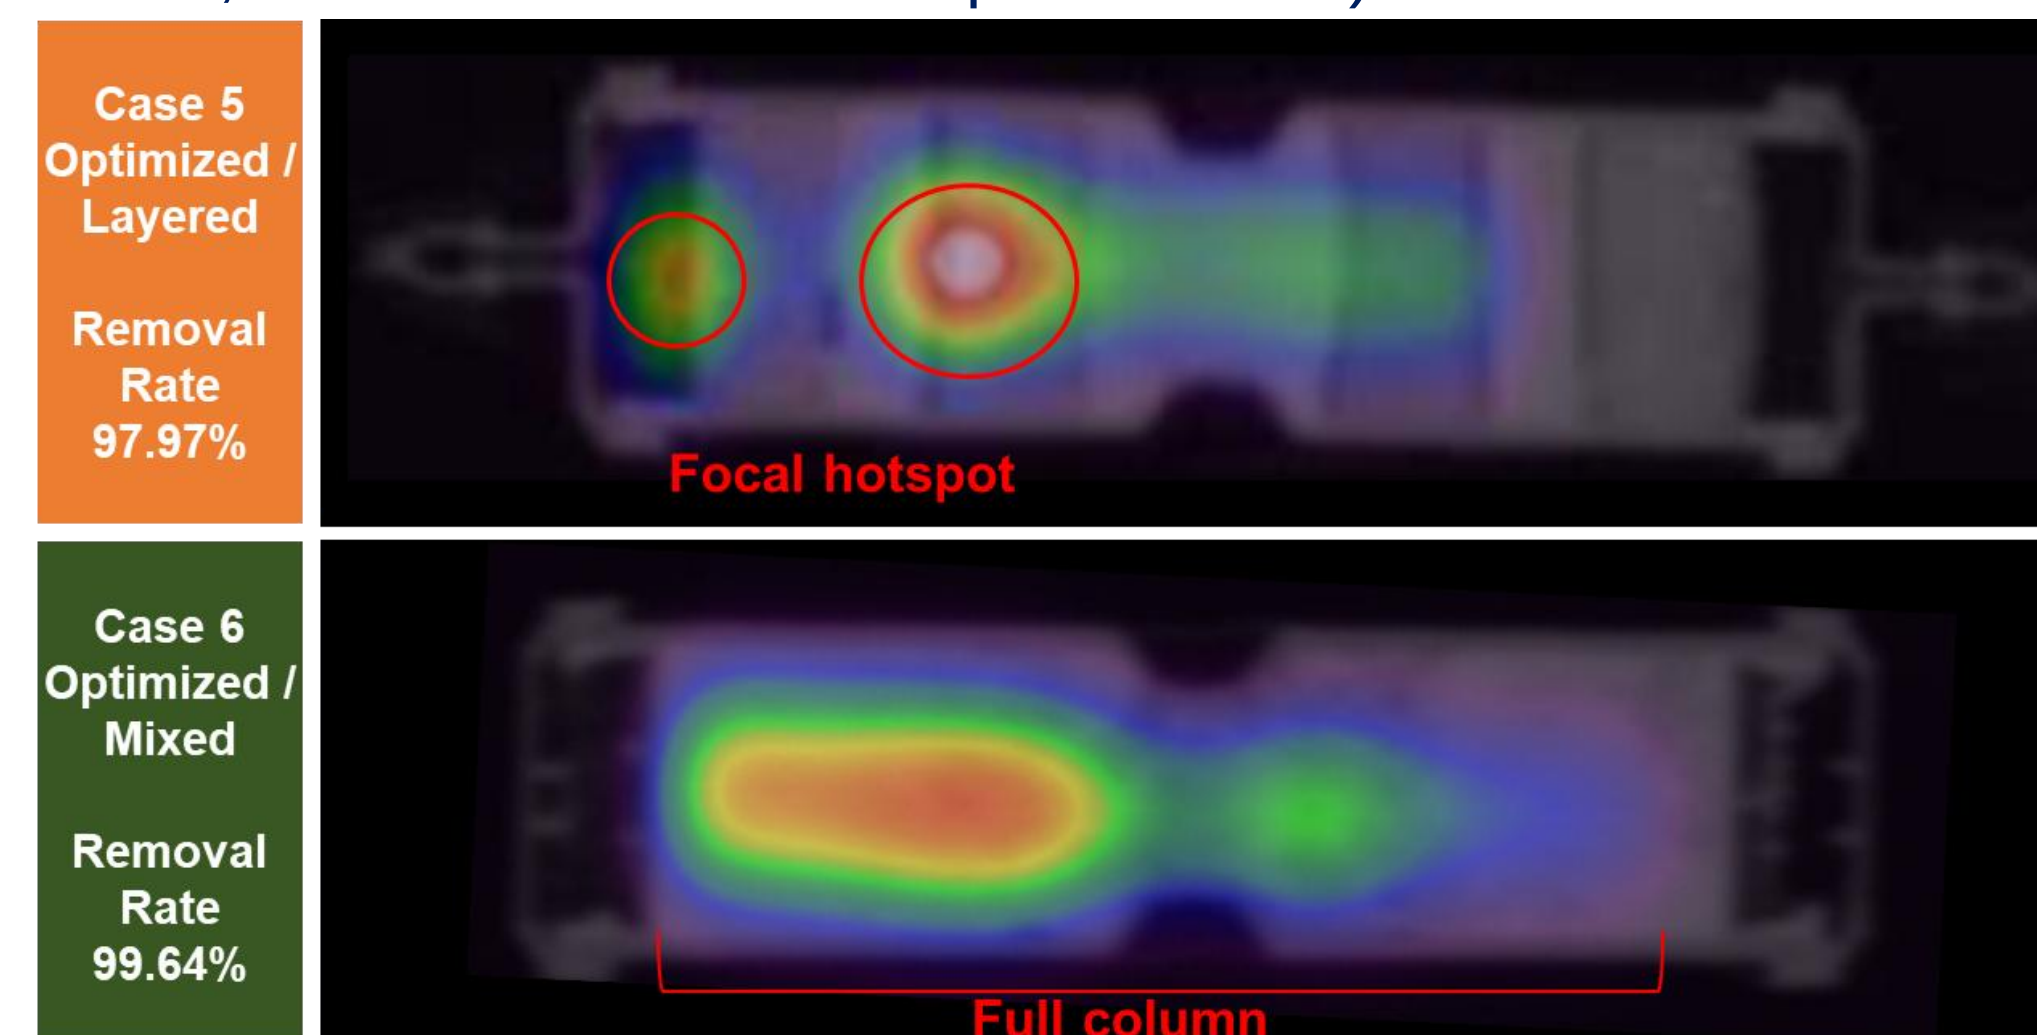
SPECT Imaging of ^{177}Lu Distribution: Non-uniform (Case 5, Standard / Layered) vs. Uniform (Case 6, Optimized / Mixed)
